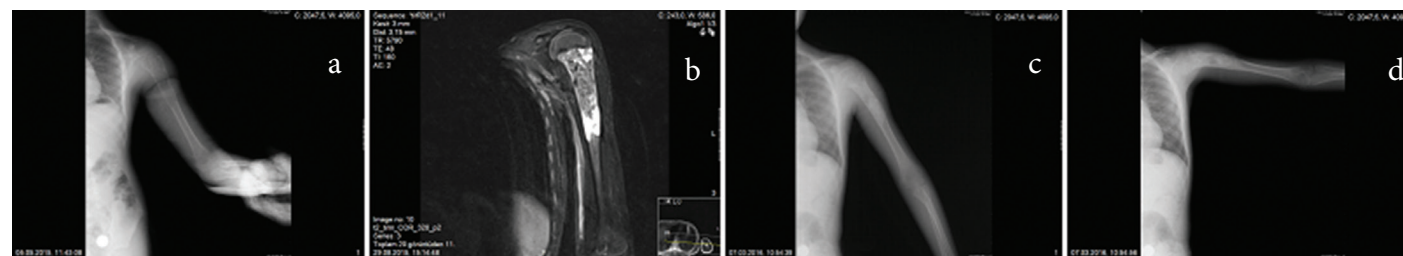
Anteroposterior (AP) direct radiography of the preoperative humerus of a 10-year-old male patient with an UBC. Figure 1b. Preoperative MRI image of the patient. Figure 1c and 1d. AP-lateral radiography of the humerus of the patient in the postoperative first year.
